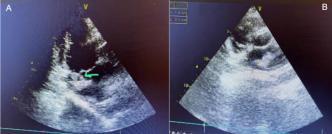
(A) Transthoracic echocardiogram (parasternal long axis view), green arrow shows the vegetation attached to the left atrium.
